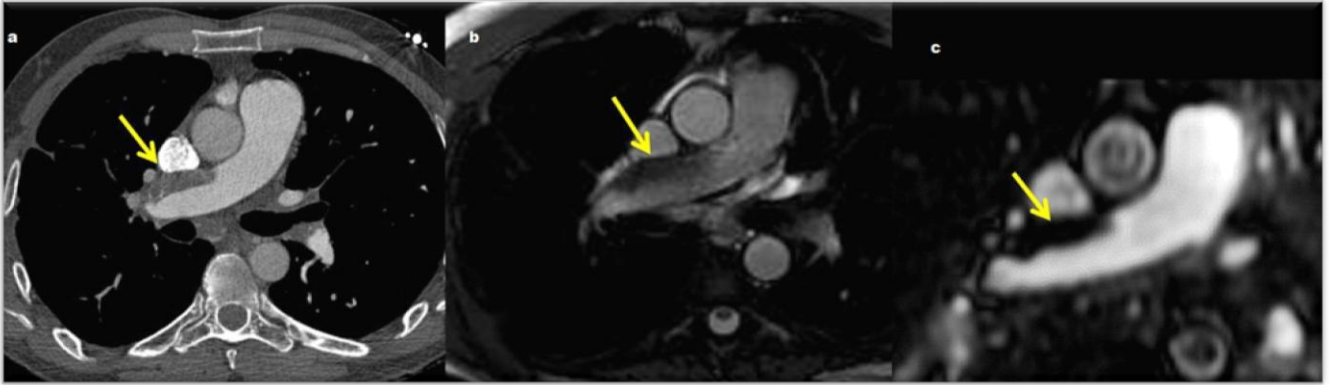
CTPA (a), unenhanced bSSFP MRI (b) and CE-MRA (c) show thromboembolic material adherent to the right main pulmonary arterial wall
